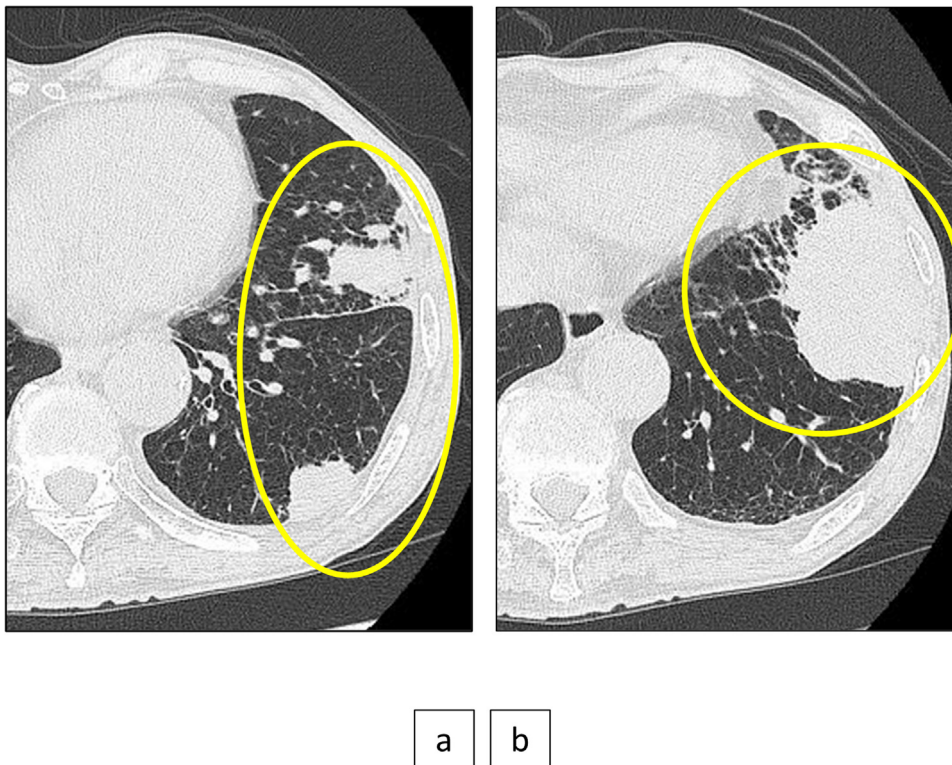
CT shows an existing squamous cell carcinoma.
